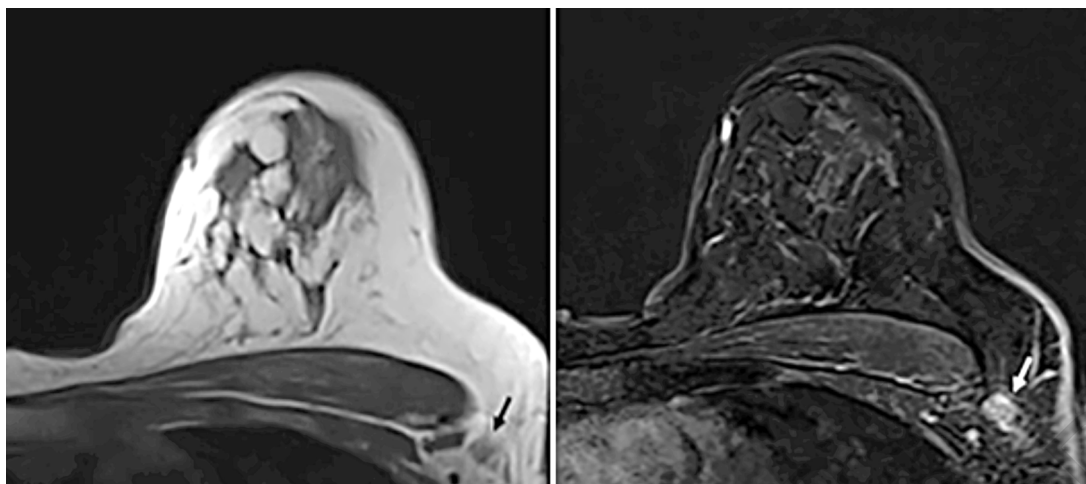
Magnetic resonance imaging (MRI) of breast. A 38-year-old woman with a 22 mm mass of grade III invasive ductal carcinoma in the left breast, estrogen receptor (+), progesterone receptor (-), Human Epidermal Growth Factor Receptor-2 (-). (1a) T1-weighted axial without fat suppression and (1b) T1-weighted post-contrast fat-suppression images of a suspicious lymph node (marked with arrow) in round shape, with no visible fatty hilus. Metastasis was not detected in 7 sentinel lymph nodes.
